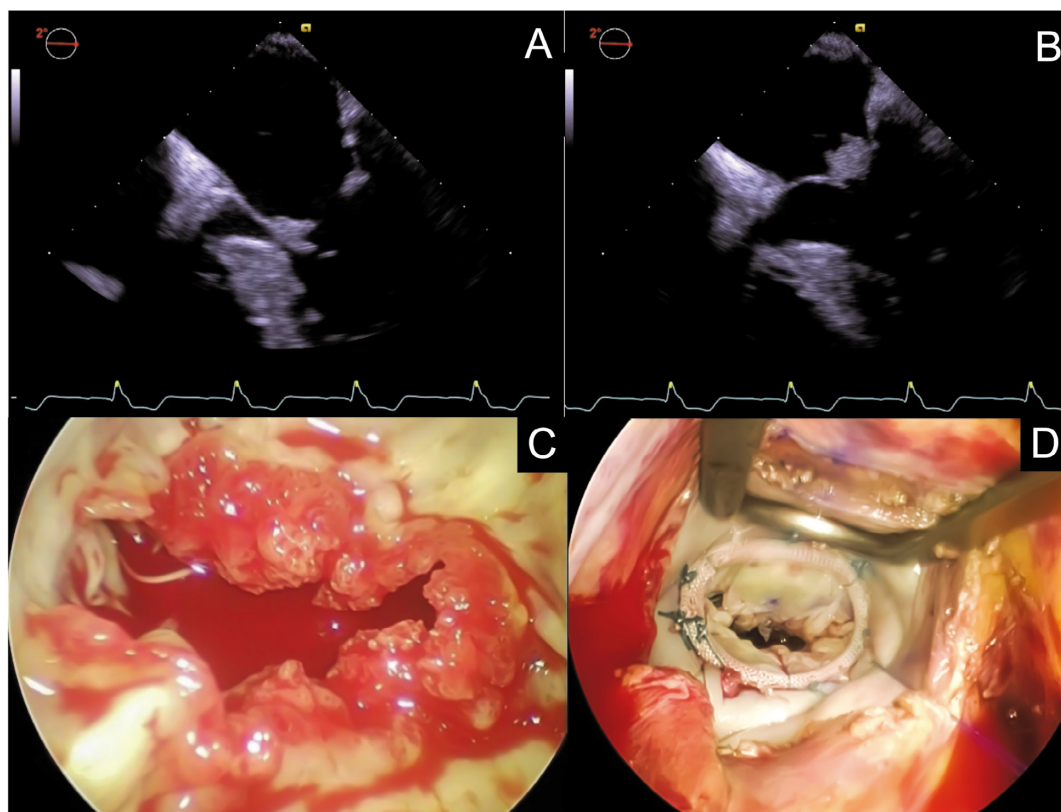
(A,B) Transesophageal echocardiogram showing large mobile vegetation on the mitral valve leaflets. (C) The anterior and posterior mitral valve leaflets covered with extensive vegetation. (D) The mitral valve after debridement and annuloplasty.
